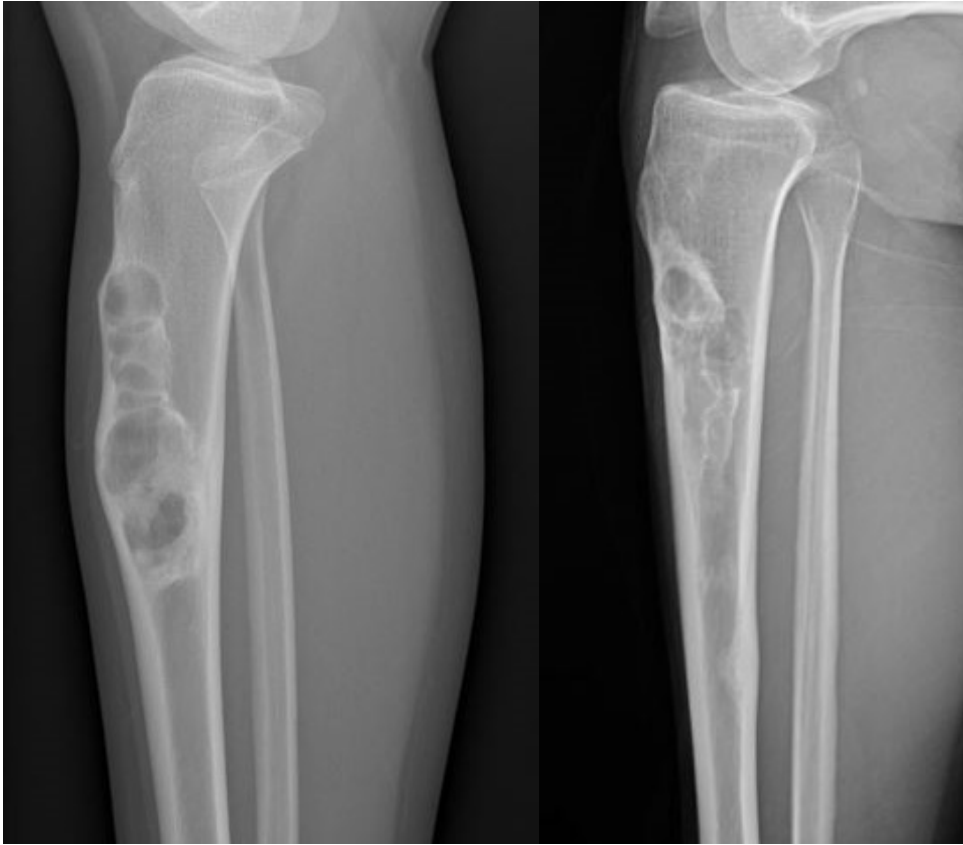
Plain radiographs of the tibia with cortical expansion (left) and intramedullary expansion (right)
